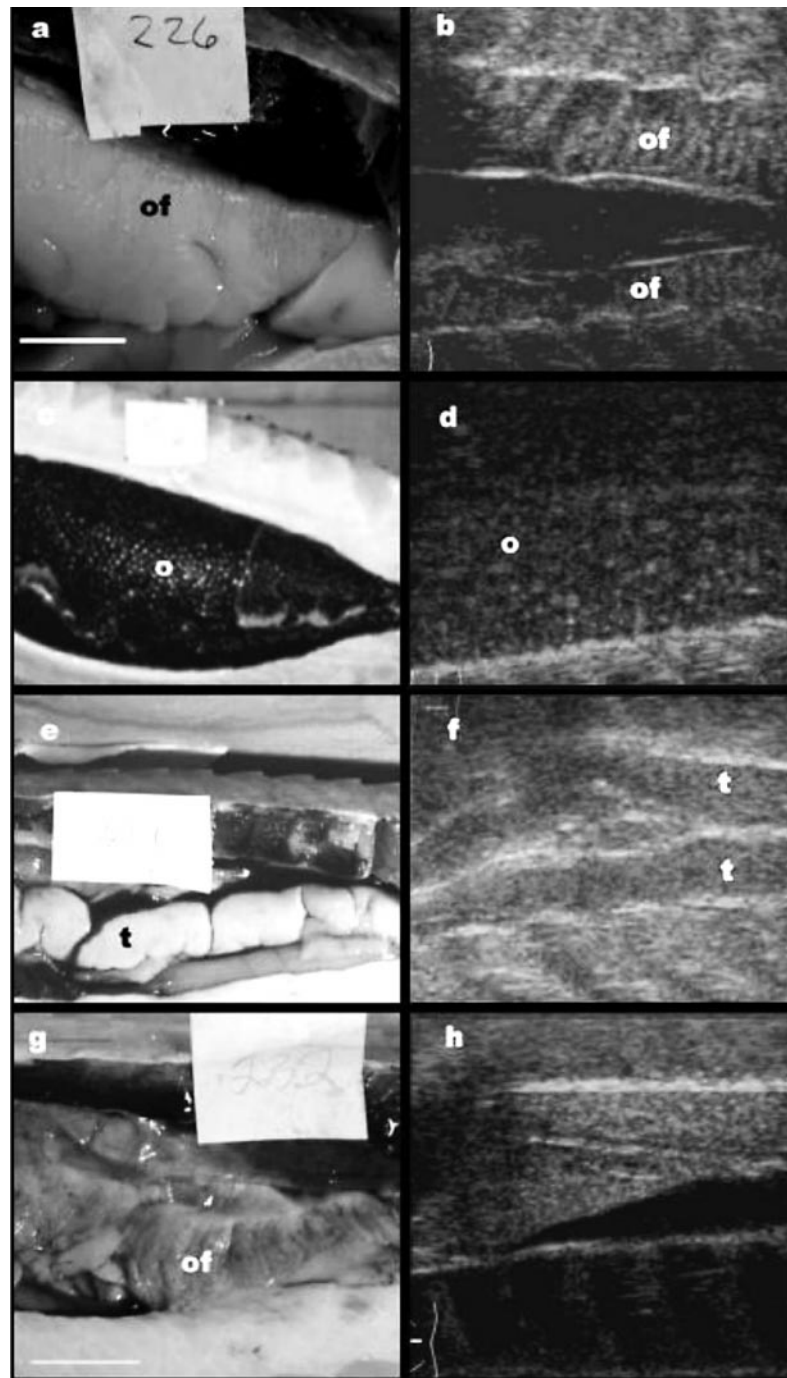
Ultrasound (UL) and eviscerated (EV) images of shovelnose sturgeon gonads: (a) EV, undeveloped female; (b) UL, undeveloped ovary (note ovarian folds); (c) EV, mature ovary (note black eggs); (d) UL, mature ovary (note oocytes; about 2 mm); (e) EV, mature testis; (f) UL, mature testis; (g) EV, postspawned ovary; and (h) UL, postspawned ovary (where, of = ovarian fold, t = testis, o = oocyte).
